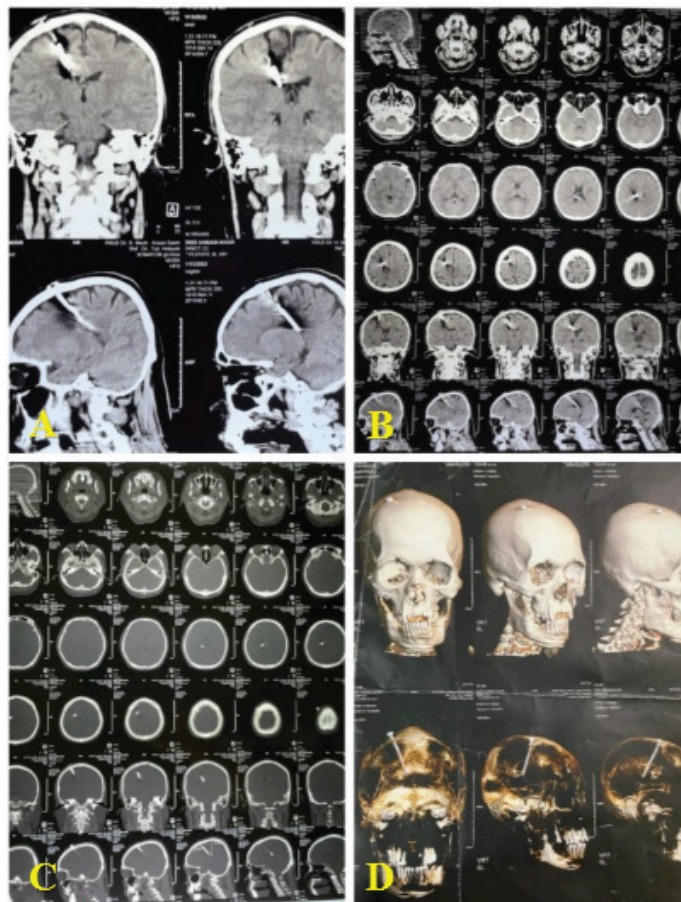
Patient Head CT Scan Pre-Operation (A-D)
